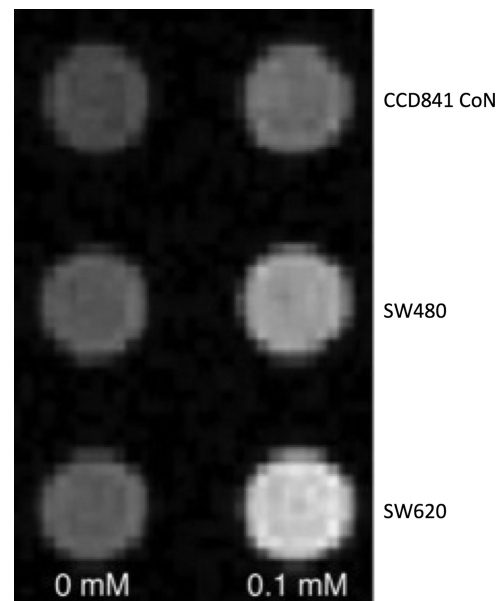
Images were acquired on a clinical 3.0 T MRI scanner with an 8-channel head coil. The temperature in the scanner bore was 25°C. Both T1-weighted image (T1WI) and T1 map images were acquired in the axial plane. First, a 2D spin echo T1WI (2D SE T1WI) was performed with following parameters: repetition time (TR) = 597.22 milliseconds, echo time (TE) = 12.40 milliseconds, field of view (FOV) = 60 mm, section thickness = 1 mm, section interval = 1 mm, number of acquisitions = 20, matrix = 144 × 144. Further, a 2D inversion recovery turbo spin echo (2D IR TSE) for determination of a T1 map was performed: TR = 3000 milliseconds, TE = 18.5 milliseconds, TI = 50, 100, 250, 500, 750, 1000, 1250, 1500, 2000, 2500 milliseconds. FOV = 60 mm, section thickness = 1 mm, section interval = 1 mm, number of acquisition = 20, matrix = 144 × 144. The data calculation and analyses were conducted using a custom program developed in MATLAB (version 7.0; MathWorks, Natick, MA). Both T1 relaxation times with and without Mn administration were calculated on a pixel-by-pixel basis. Three independent measurements were made, and the average values were recorded. The average T1 value shortening was defined as subtraction of average T1 values in 0 mM and 0.1 mM concentrations. The ROI (region of interest) was manually encircled at the cell pellets section with an area of about 7 × 7 mm<sup>2</sup>.
